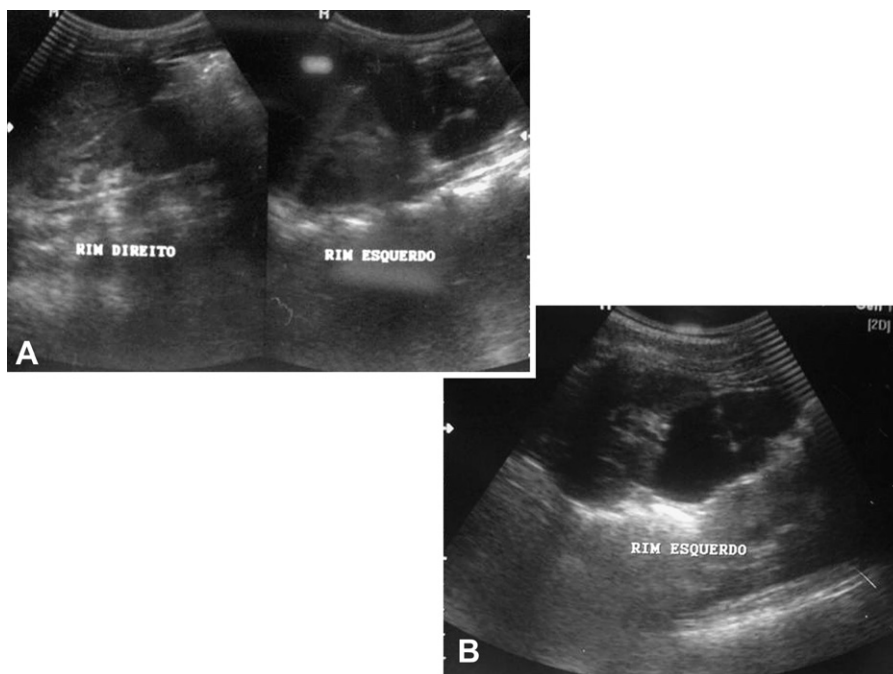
Ultrasonography reveals multiple cysts affecting only the lower pole of the left kidney.
